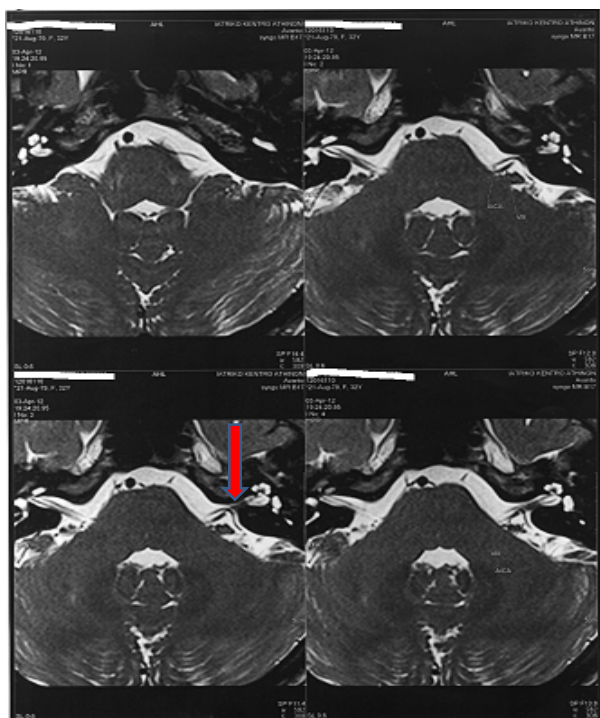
Axial MRI shows a vascular loop from the AICA (horizontal arrow) in contact to the VIII cranial nerve (vertical arrow) within the cerebellopontine angle and outside the internal acoustic channel .
